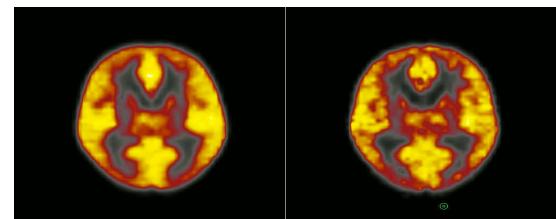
Mean MR images of 6 SMI patients (left) and 8 AD patients (right).
